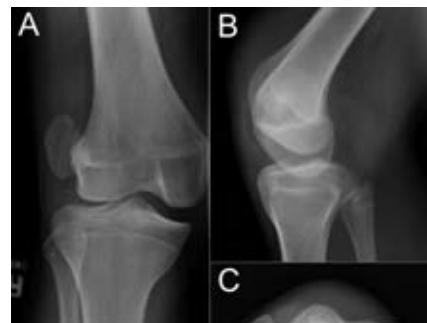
AP (A), lateral (B) and Merchant (C) radiographic views of the patella demonstrates the patella dislocated in the lateral gutter. On the Merchant view (C), femoral trochlea dysplasia is not seen. This was further confirmed intraoperatively.
